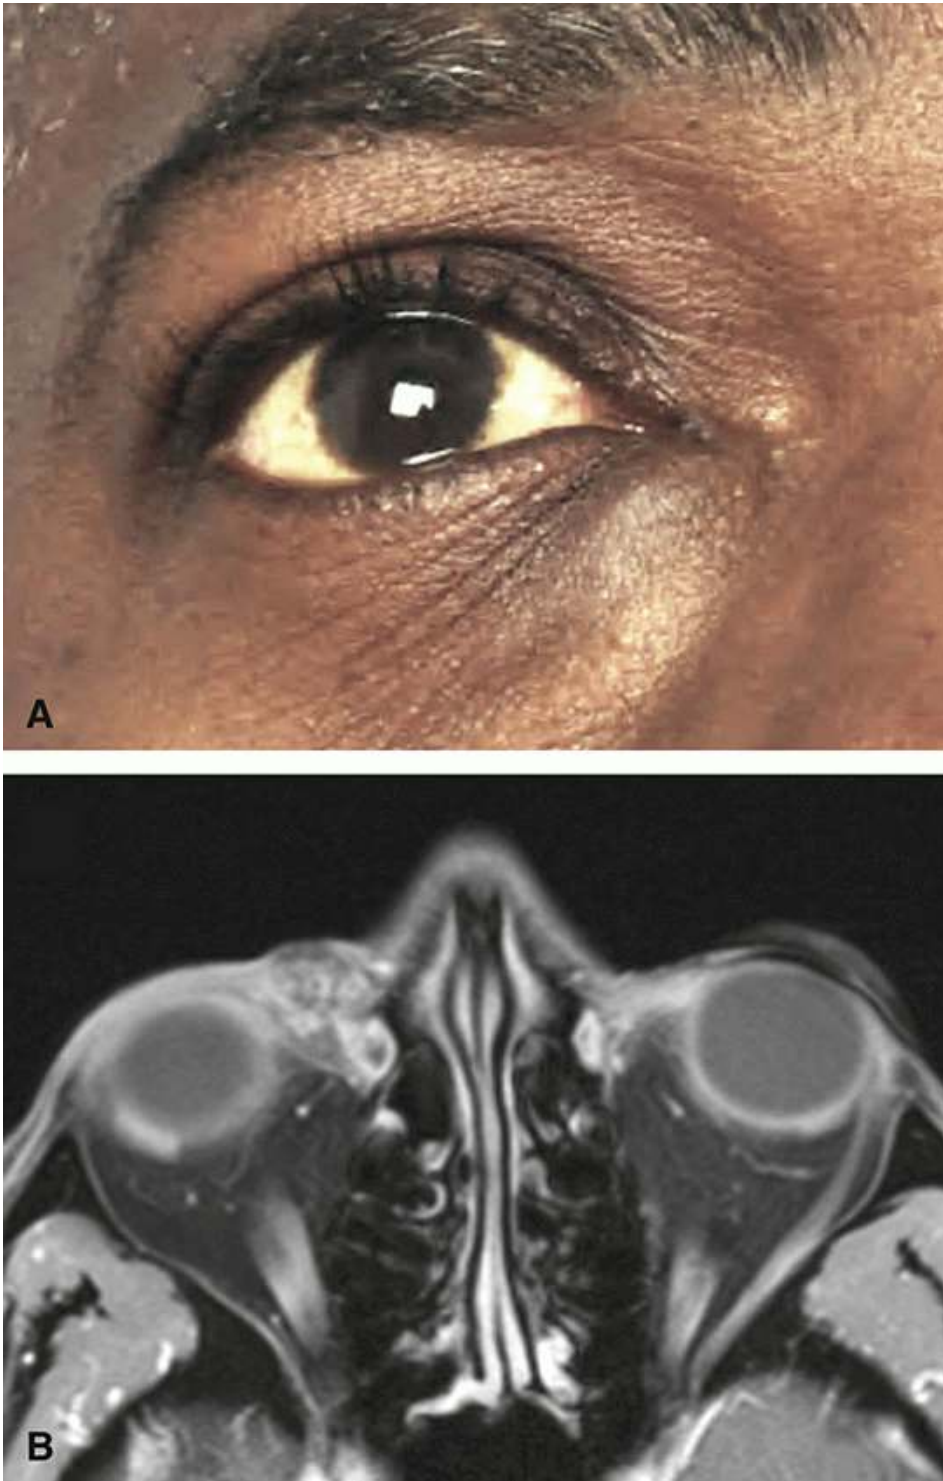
A, An anteriorly located orbital cavernous venous malformation that protrudes through the eyelid skin. B, Axial CT scan of the right orbit showing the anteromedial CVM. (A and B, Courtesy of Dr Daniel Rootman.)
